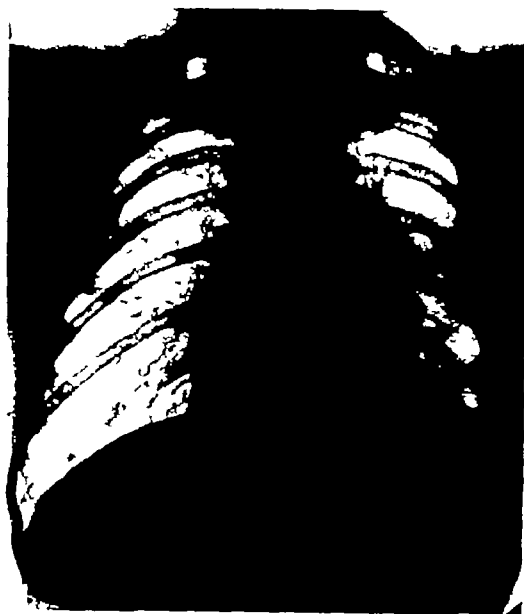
Same case as shown in Figures 12-14. After x-ray and radium treatment the greater portion of the findings shown in Figures 12 and 13 have disappeared. There has been a shifting of the heart shadow back toward the normal position.
